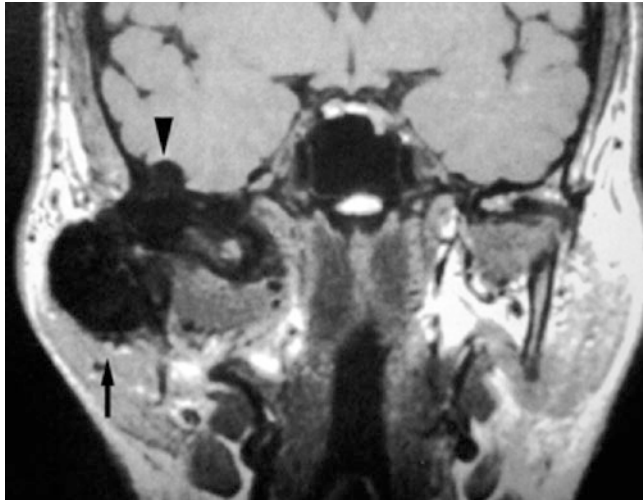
Pigmented villonodular synovitis. Coronal T1-weighted MRI shows large mass of very low signal (*arrow*), penetrating skull base (*arrowhead*). Very low signal also characteristic on T2-weighted and post-Gd MRI (not shown) (courtesy of Dr. T. Larsson, Seattle, Washington)
